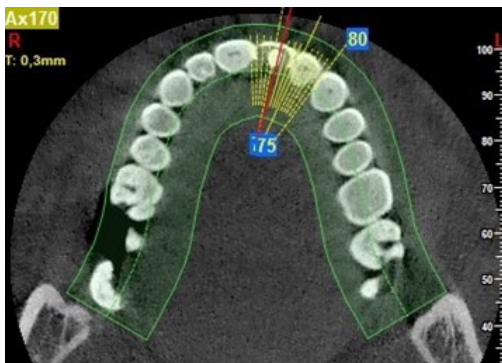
CBCT scan of the patient.
